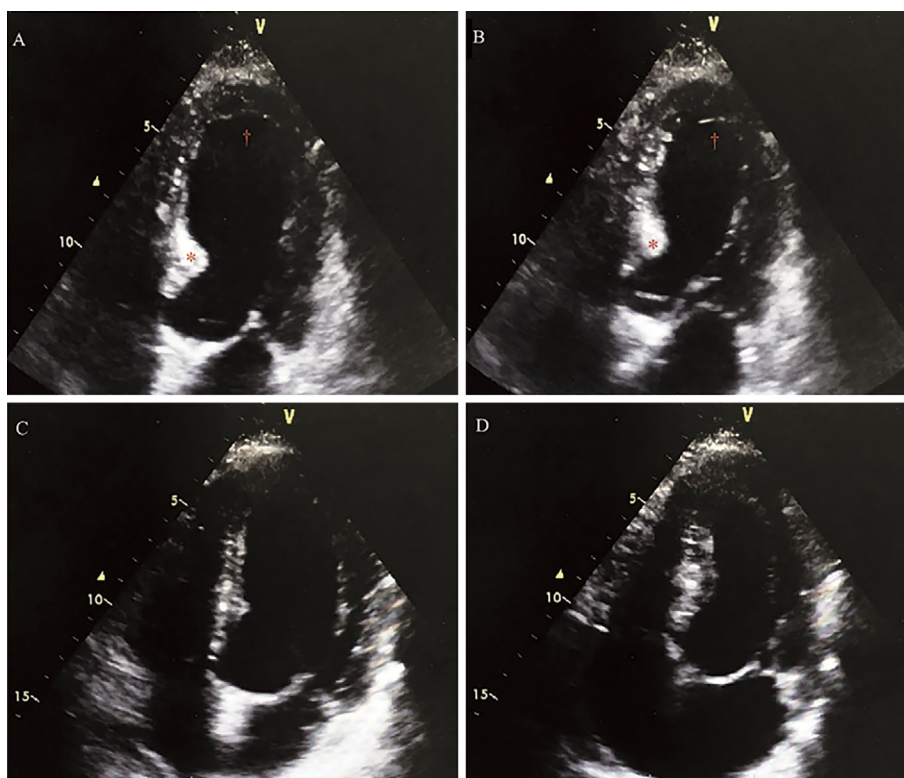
Two-dimensional echocardiogram. Two chamber view of the left ventricle during diastole (A) and systole (B) showing akinetetic and balloon apex in systolic (*) and alternatively normal contractile base (†), consistent with the findings in Takotsubo syndrome. After 14 days, wall motion normalized in diastolic (C) and systolic (D) phases. Two-dimensional echocardiogram.
